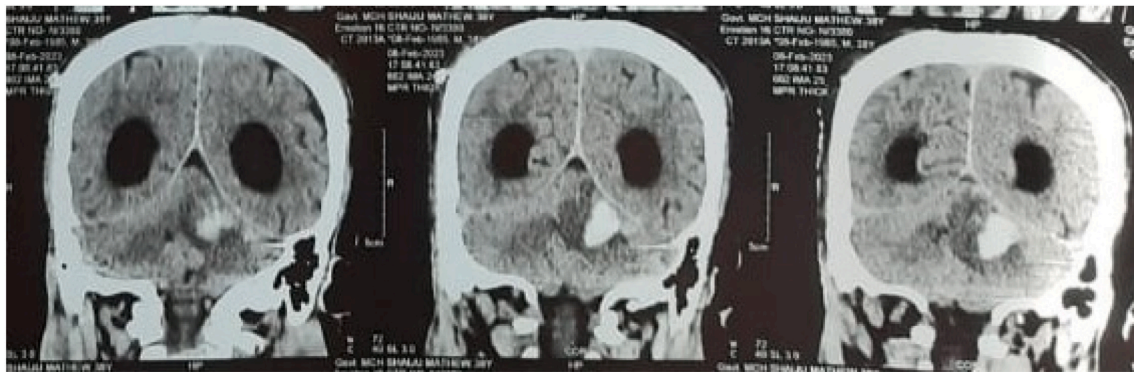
are the magnetic resonance imaging of brain showing a well-defined lesion in the posterior fossa, on the left side with contrast uptake and ring enhancement of the wall.
